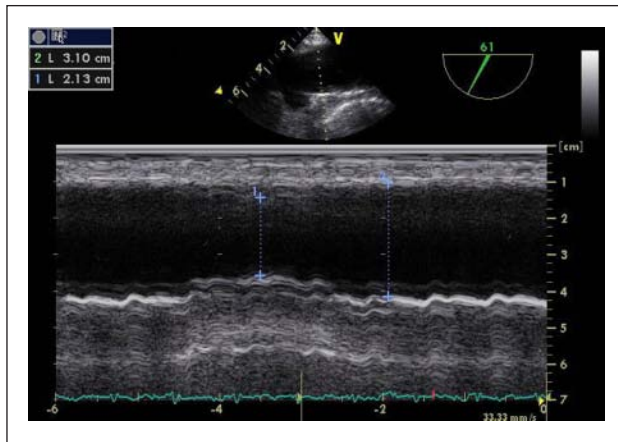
M-mode interrogation of superior vena cava (SVC) by transesophageal echocardiography
